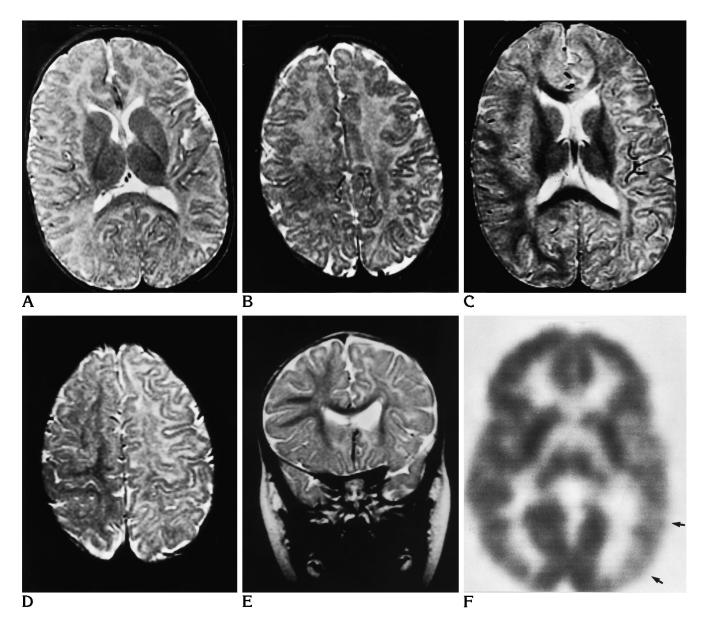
A and B, MR at 6 months of age. A, Axial T2-weighted image (2200/80/1 [repetition time/echo time/excitations]), at the level of the internal capsule. T2 myelination changes are present in the splenium of the corpus callosum and in the internal capsule bilaterally. Overall white matter development was reported as normal, although in retrospect some early mild asymmetry in the genu of the corpus callosum may have been present.
